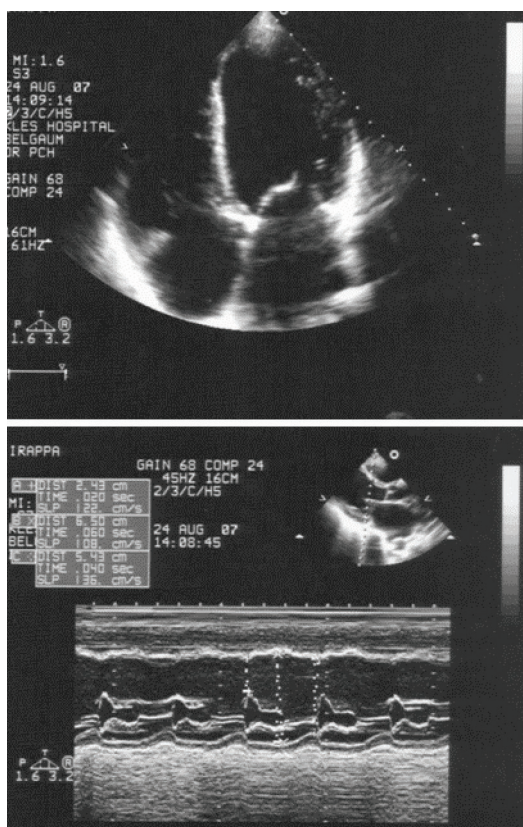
M mode echocardiography in dilated cardiomyopathy
